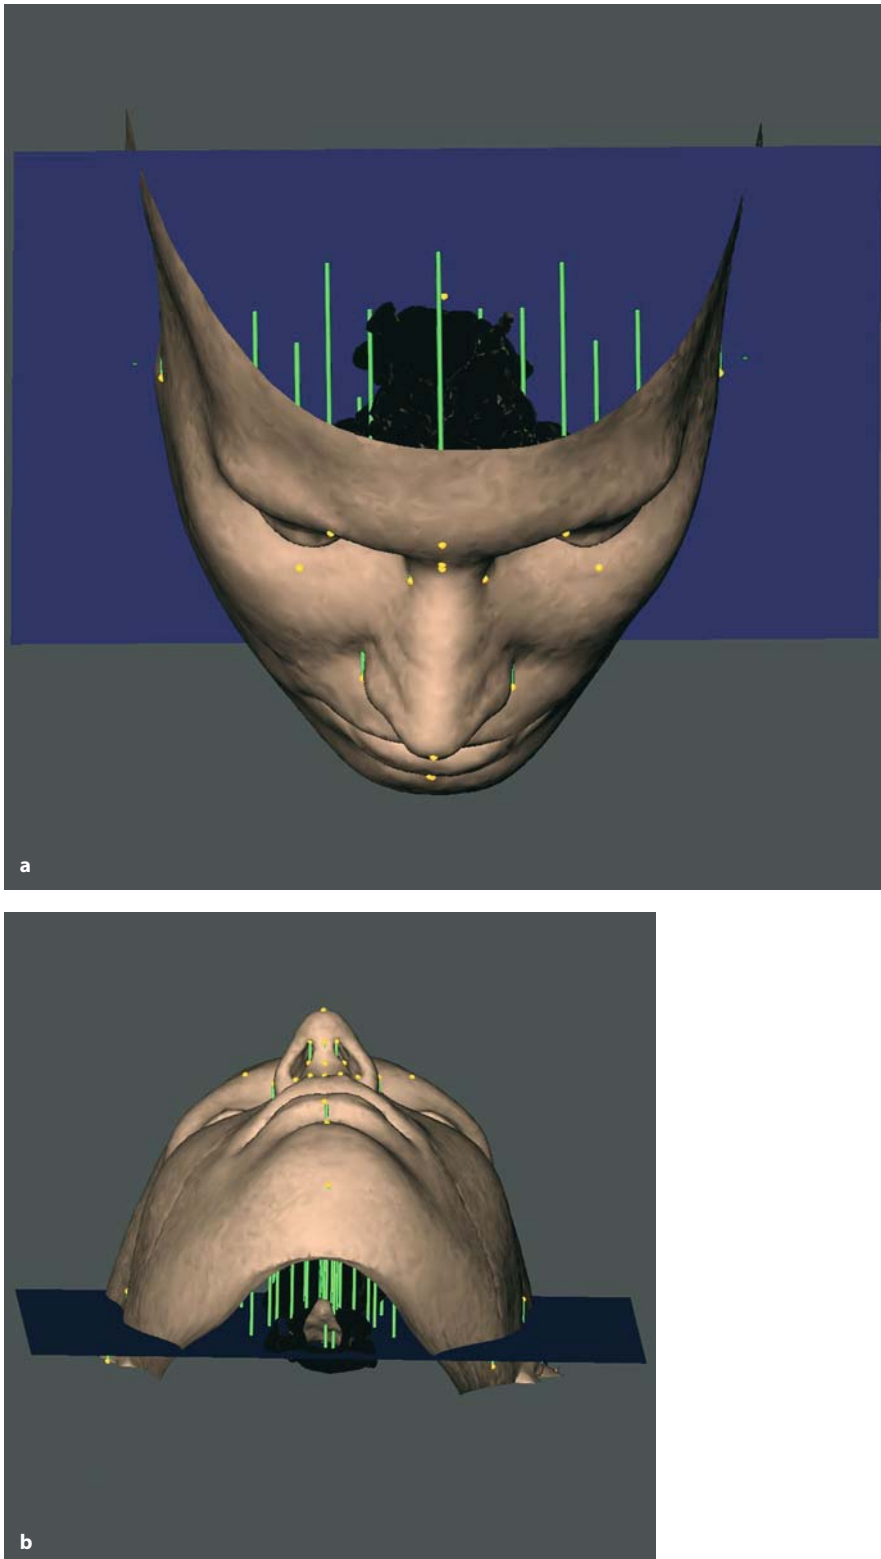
a, b. Set-up of horizontal orthogonal soft tissue measurements to the y-plane (3-D CT, patient K.C.)
